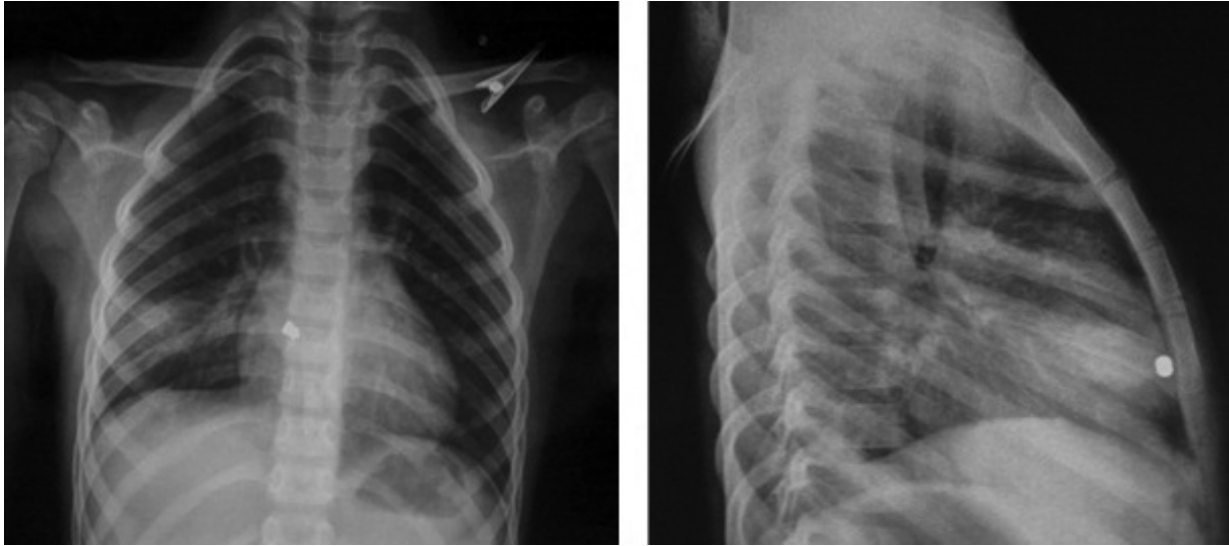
Anteroposterior and lateral chest radiographs with radiopaque pellet visualized in the anterior mediastinum.
